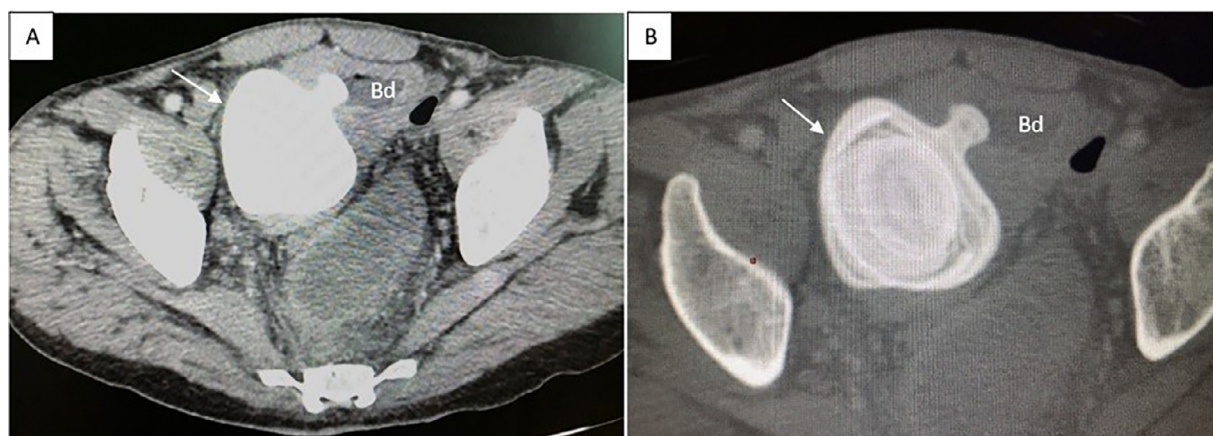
CT scan of the abdomen in axial section and bone window reveals a large stone (white arrow) located in a right lateral diverticulum of the bladder (Bd).
